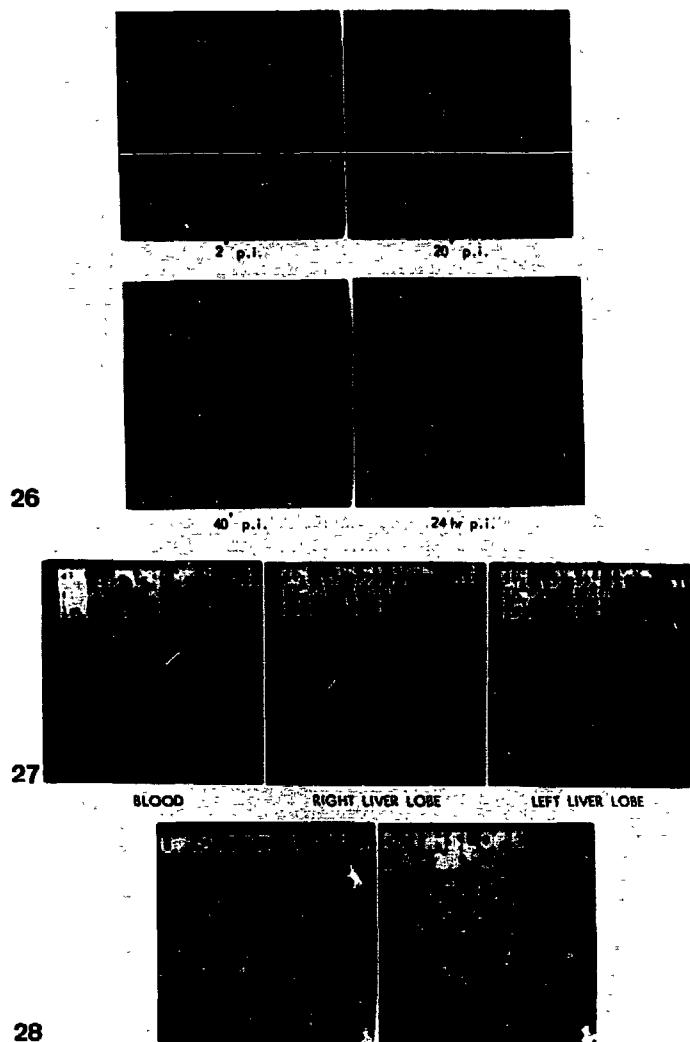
26-28 Cholescintigraphy in a patient with drug induced hepatitis.
